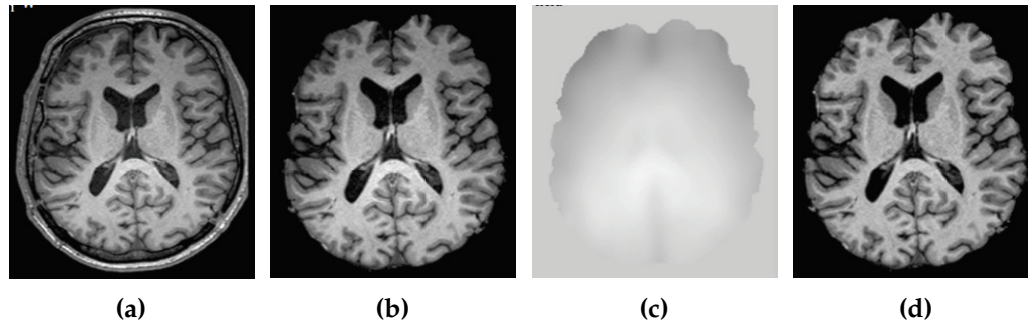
Pre-processing steps: (a) raw brain MRI scan in T_{1w} MRI sequence; (b) brain MRI scan after skull-stripping; (c) the bias field; (d) brain MRI scan after bias field correction. Images taken from [Despotović et al. \(2015\)](#).
